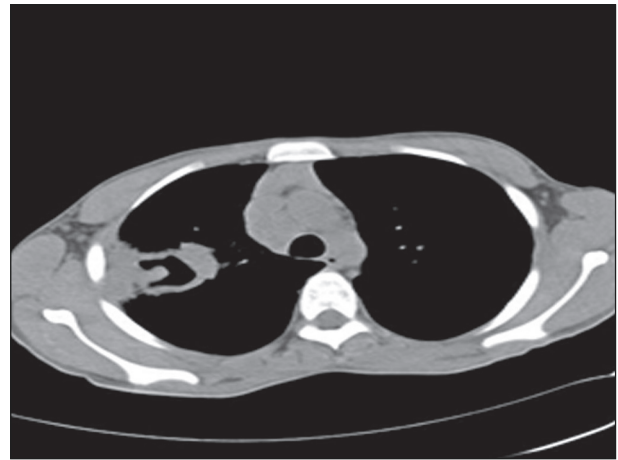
Computed tomography of chest shows irregular thick walled cavitary lesion with surrounding air space consolidation in the right upper lobe with ground glass opacity in the posterior segment of right upper lobe
